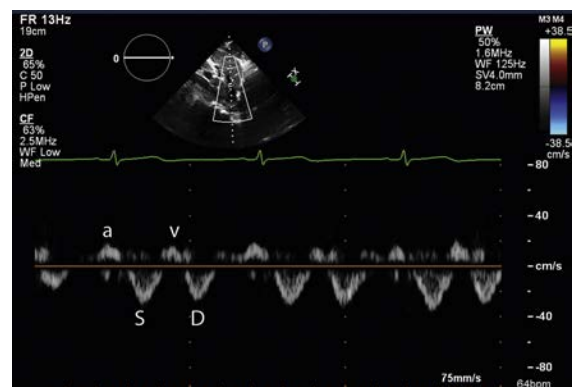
Hepatic vein flow. Pulsed Doppler velocities are recorded from the subcostal view to evaluate right atrial filling when tricuspid regurgitation or pericardial disease is of concern. *a*, Atrial; *D*, diastolic wave; *S*, systolic wave; *v*, ventricular.
